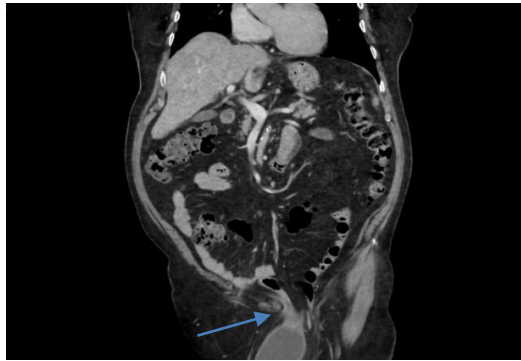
Coronal reformat of the CT image showing the herniated bladder into the left inguinal canal (long arrow).
